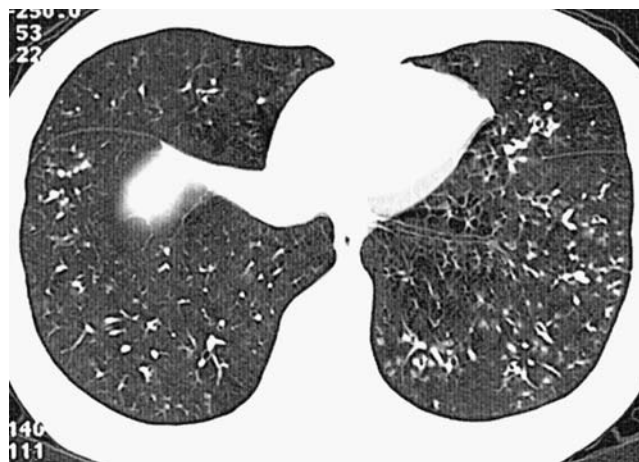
Chest computed tomography (CT) scan, showing diffuse ground-glass opacities and septal thickening, particularly in the upper lobe of the left lung
